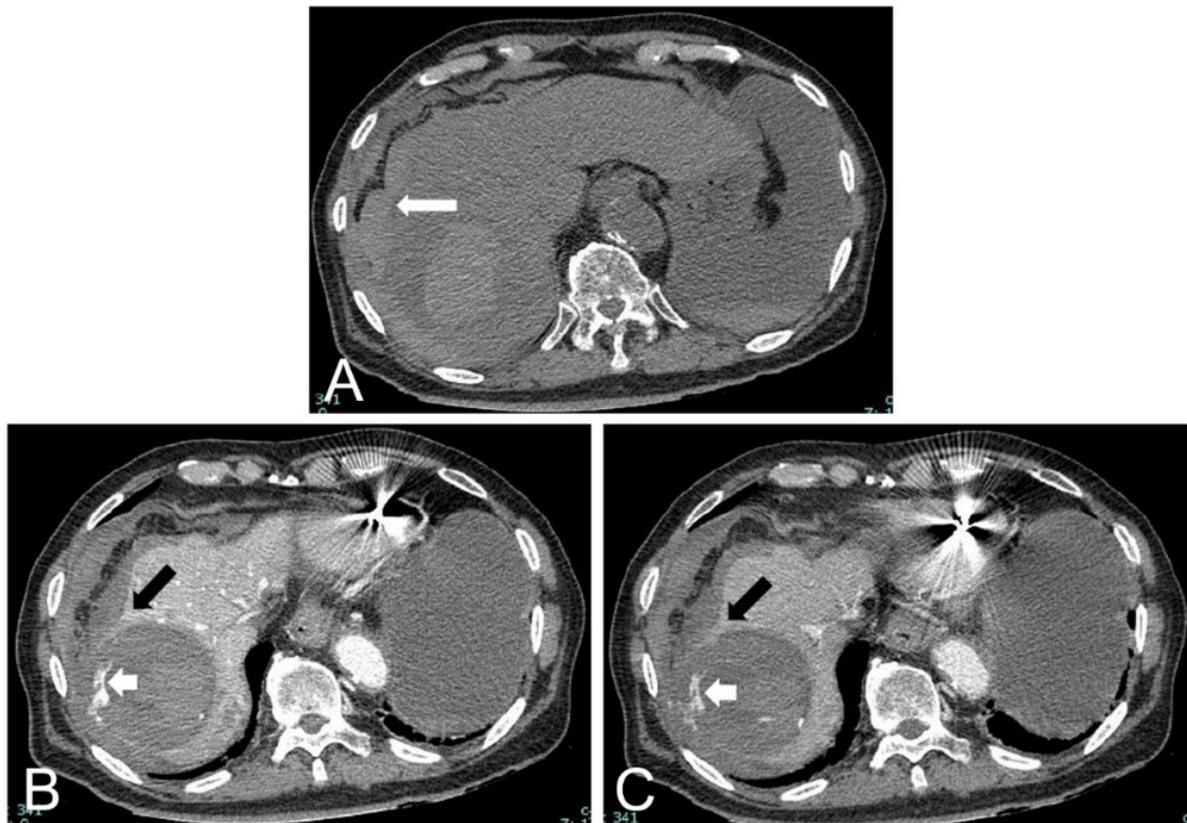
A 81-year-old male with anemia (Hct 22.9%), epigastric distension and tenderness. A. Non-contrast phase CT scan shows hyperattenuating hematoma at the lateral aspect of the right hepatic lobe (long arrow). B. Arterial and C. Delayed phase CT scans show a well-defined arterial enhancing mass at hepatic segment 7, which demonstrated hepatic capsular disruption of the HCC (dark arrows) with active contrast extravasation (short arrows).
